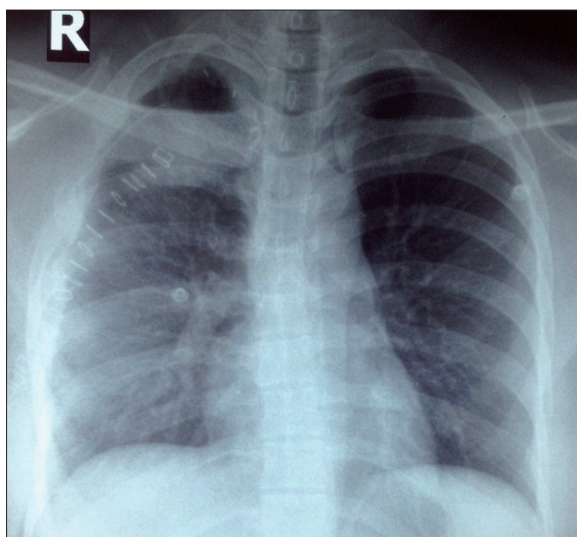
Post-operative chest X-ray showing complete excision of the 3rd rib and the lesion.
